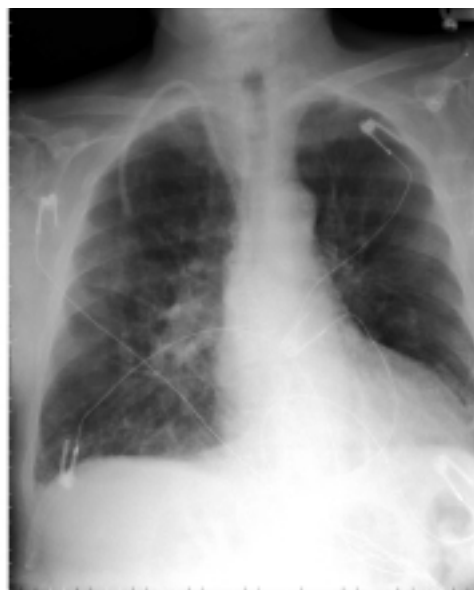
Initial emergency department chest x-ray performed on this patient, who presented with signs and symptoms characteristic of a wet and warm profile. Cardiomegaly, Kerley B lines, and pulmonary congestion consistent with congestive heart failure were noted.
